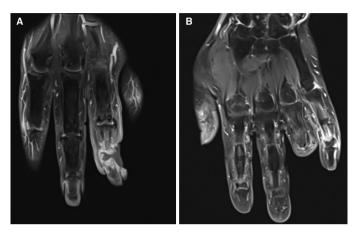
A) Magnetic resonance imaging (MRI) of the left hand before treatment. Fat-suppressed T1-weighted contrastenhanced MR image of the fourth finger of the left hand shows deformation and loss of integrity in the osseous structure of the medial and distal phalanges, contrast enhancement in the medullar osseous structure and soft tissue, a 13x13 mm abscess formation (white arrow) with fistulization to the skin and peripheral contrast enhancement at the interphalangeal joint. B) MRI of the left hand after treatment. Fat-suppressed T1-weighted MRI acquired six months after amputation of the medial and distal phalanges of the left fourth finger shows no pathological contrast enhancement in the proximal phalanx or cutaneous and subcutaneous soft tissue of the fourth finger
